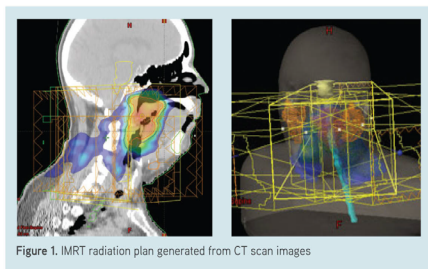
IMRT radiation plan generated from CT scan images
